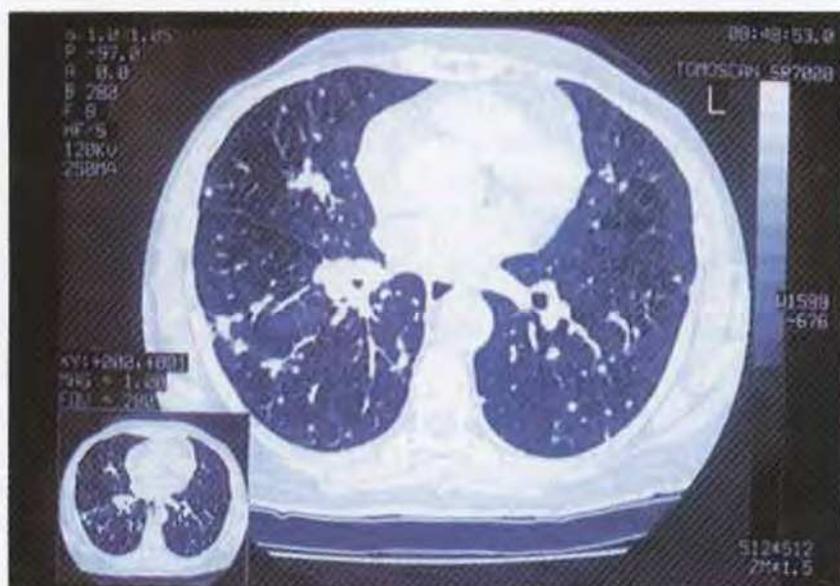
HRCT. nodules with a random distribution. Metastases from colon adenocarcinoma
